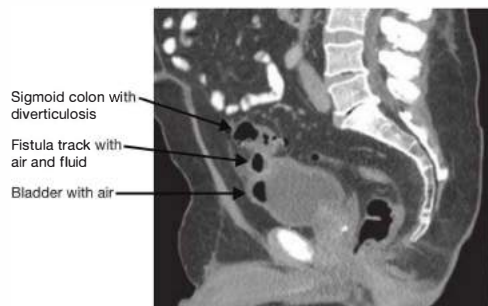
• Sagittal CT image demonstrating sigmoid diverticulitis with a fistula track and air in the bladder consistent with colovesical fistula.
